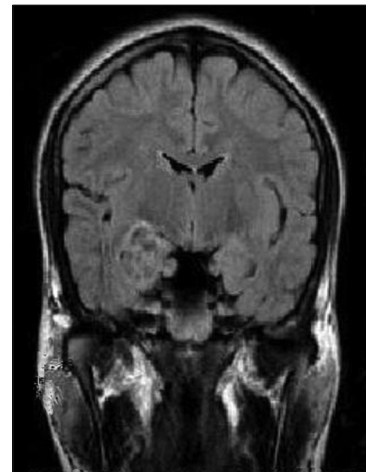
The MRI of the brain showing a hypointense mass lesion on T1, hyperintense on T2, giving a 'bubbly' appearance, and a mixed signal, with a bright rim in the Fluid attenuated inversion recovery images
